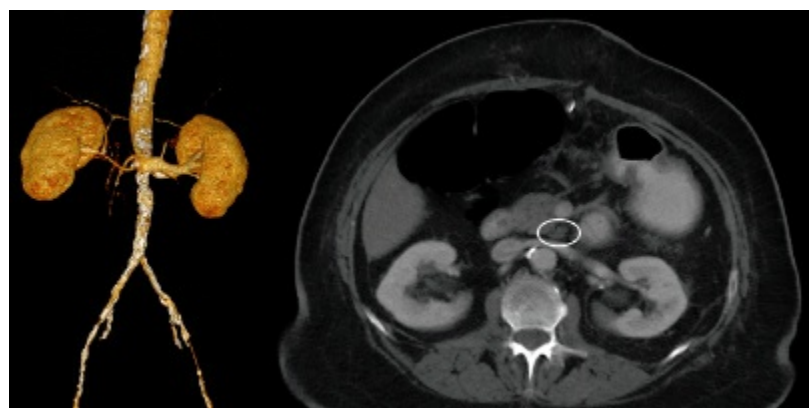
CT imaging demonstrating in situ SMA thrombosis in the setting of highly calcified aortoiliac occlusive disease and chronic celiac and IMA occlusions presenting as acute mesenteric ischemia.
